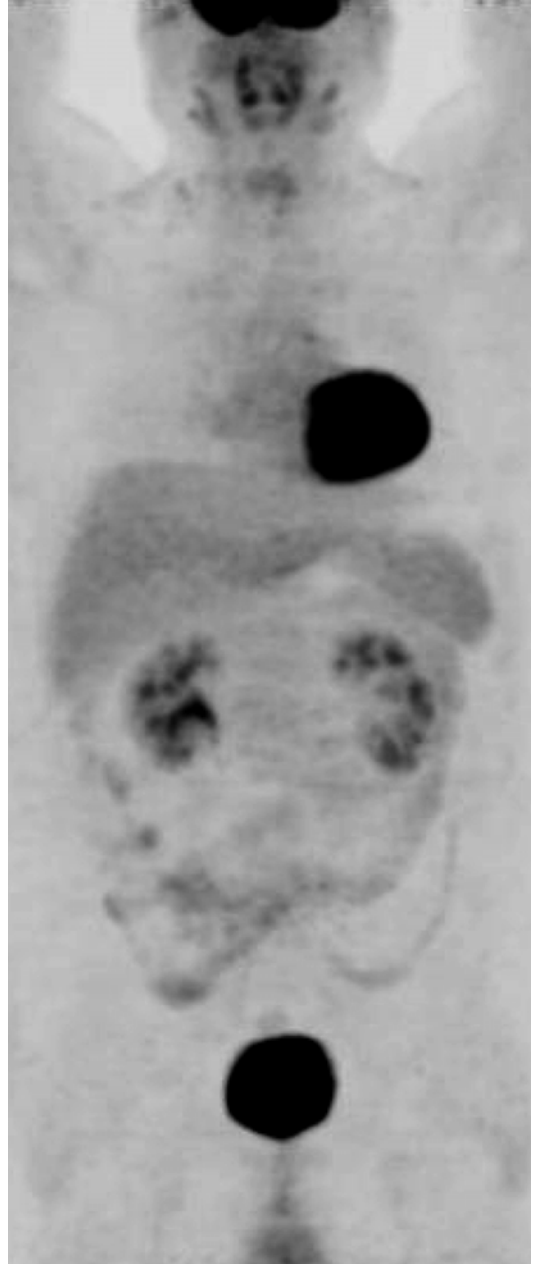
PET/CT remained negative following subsequent RT
